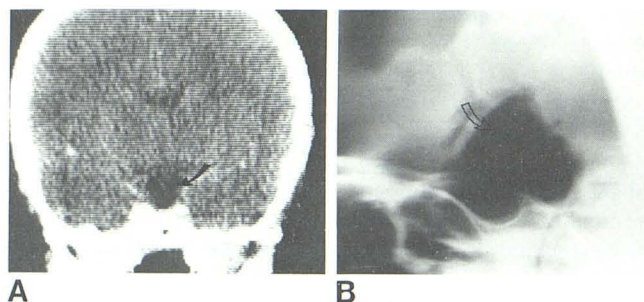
A, Coronal CT on second-generation scanner shows separation of cyst (arrow) from region of foramen of Monro. Because distinction between normal cistern and cyst could not be determined, ventriculography was performed. B, Air cisternogram demonstrates cyst filled with air (arrow).
